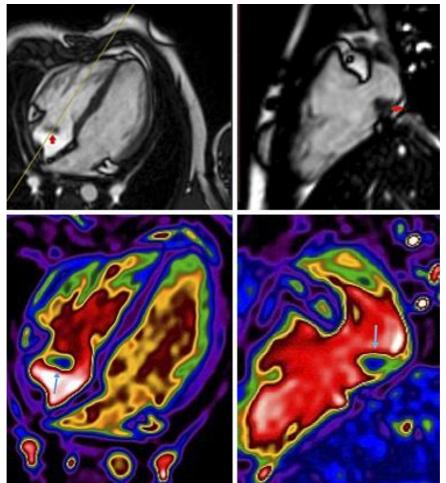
MRI showing the inmobile thrombus attached to the anterior right atrium wall
